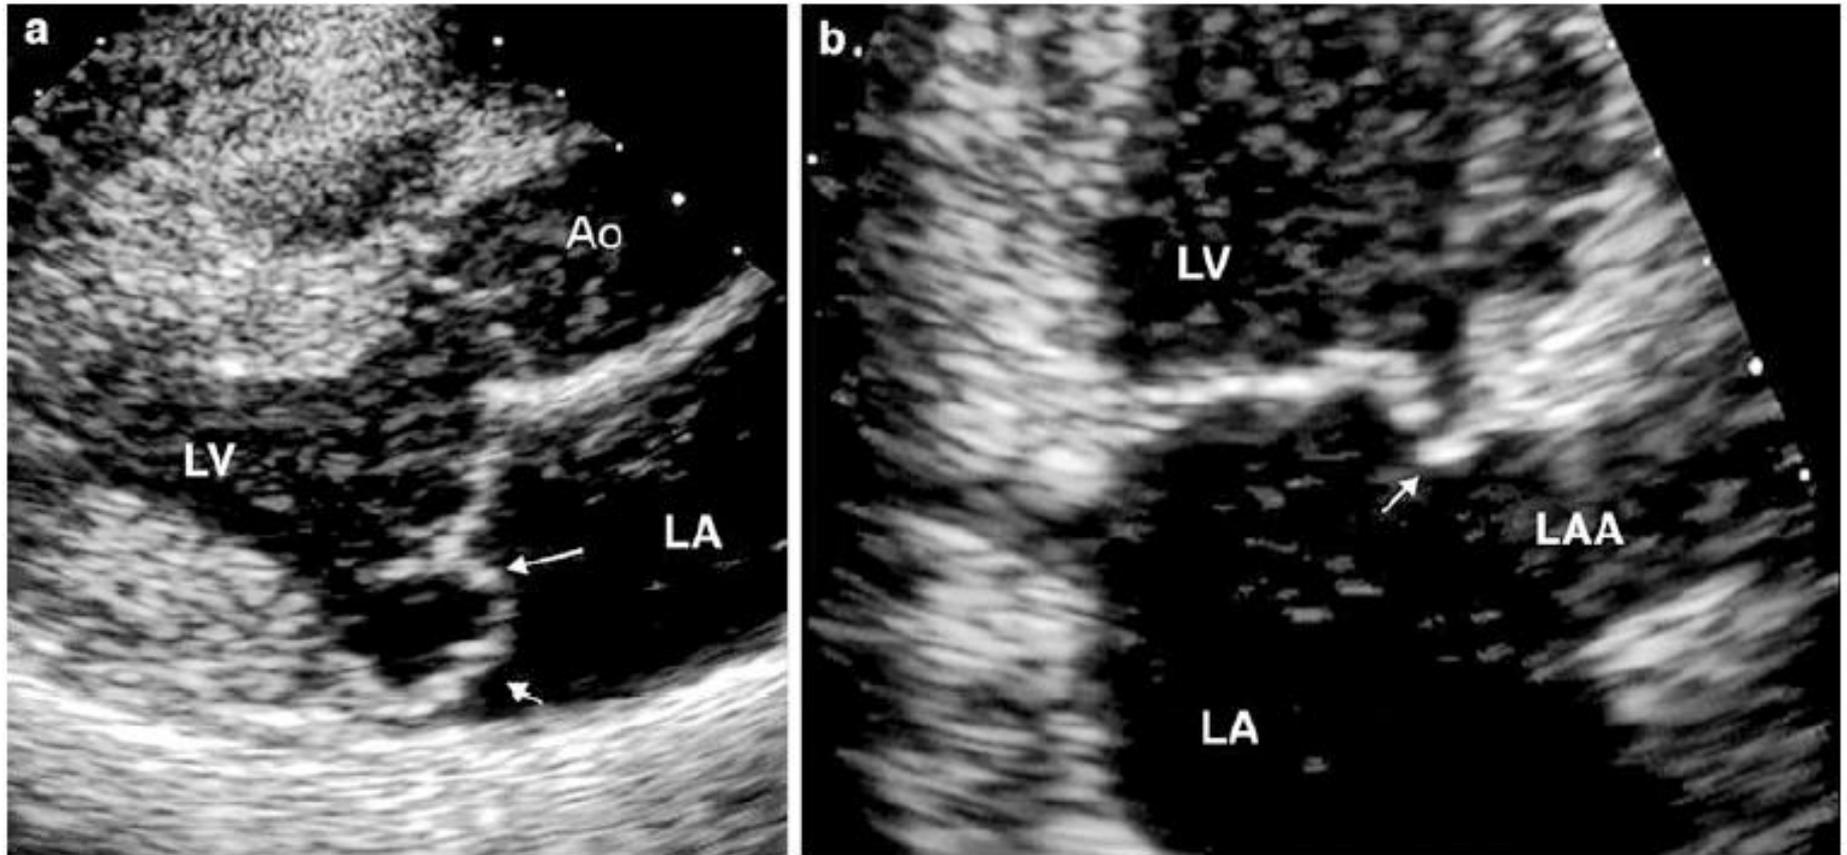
a Parasternal long-axis view showing evident prolapse of the central part (*P2*) of the posterior leaflet (arrows); b apical two-chamber view showing a small
